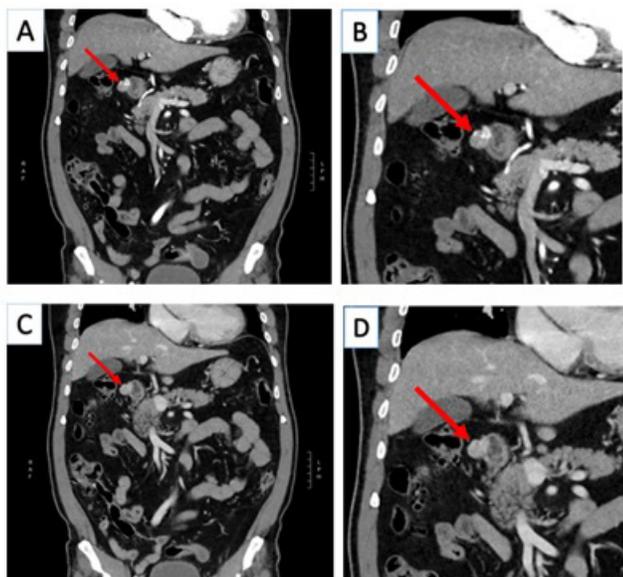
Coronal computed tomography (CT) scan demonstrated the lesion in arterial phase (A and B) and venous phase (C and D).
